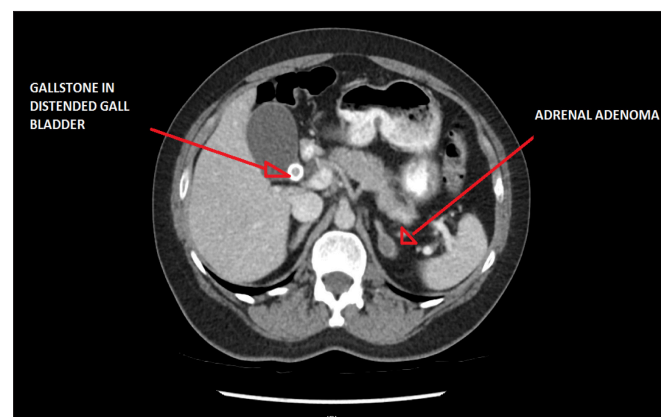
Transverse section of adrenal adenoma on CT scan.
